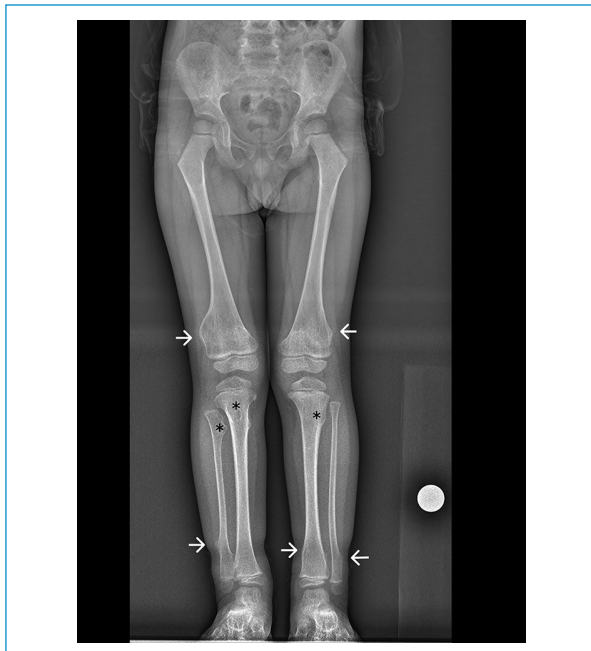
Lower limbs full-length X-ray showing multiple exostotic formations in both femurs, tibias and fibulas (white arrows and black asterisks). Note the characteristic metaphysis widening.
